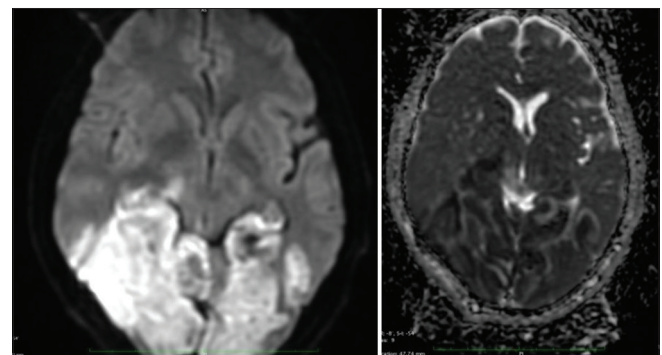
Diffusion-weighted magnetic resonance imaging images with corresponding ADC map showing a large posterior circulation infarct involving cerebellum and parieto-occipital cortex
